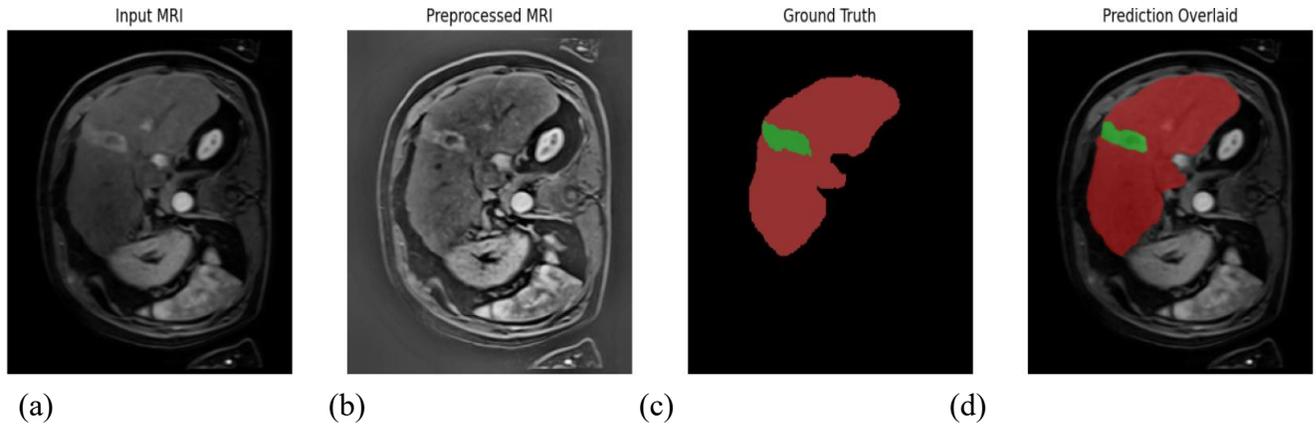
Qualitative Results of the Proposed Attention U-Net++ Model. Each row shows (A) Original MRI slice, (B) preprocessed image, (C) ground-truth image, and (D) predicted segmentation overlaid on original image (liver in red, tumor in green).
